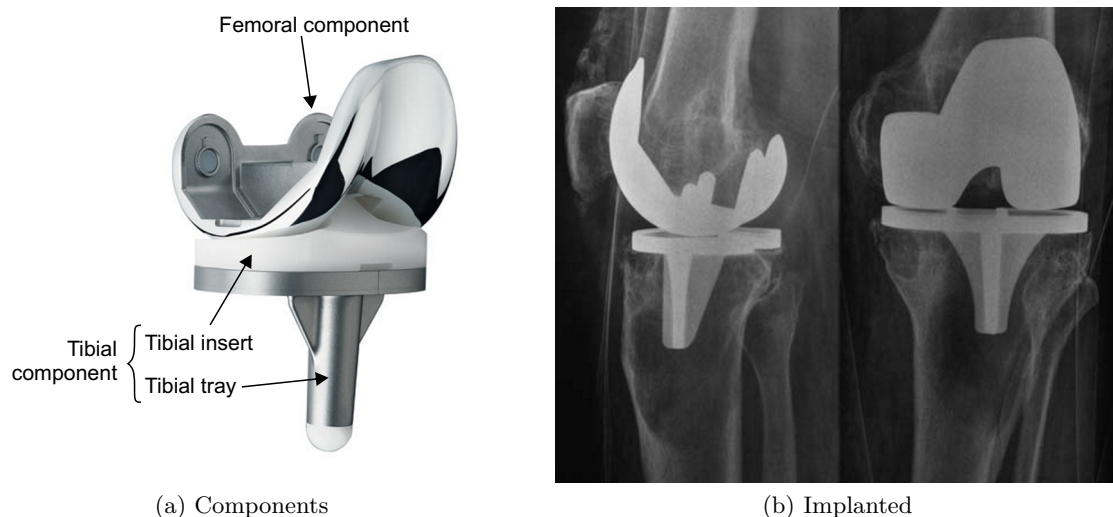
Example of a TKR: (a) is a Depuy PFC Sigma Fixed Bearing, and (b) is a patient X-ray before a revision operation (image reproduced with permission and copyright of the British Editorial Society of Bone and Joint Surgery, Baker et al., 2007).
